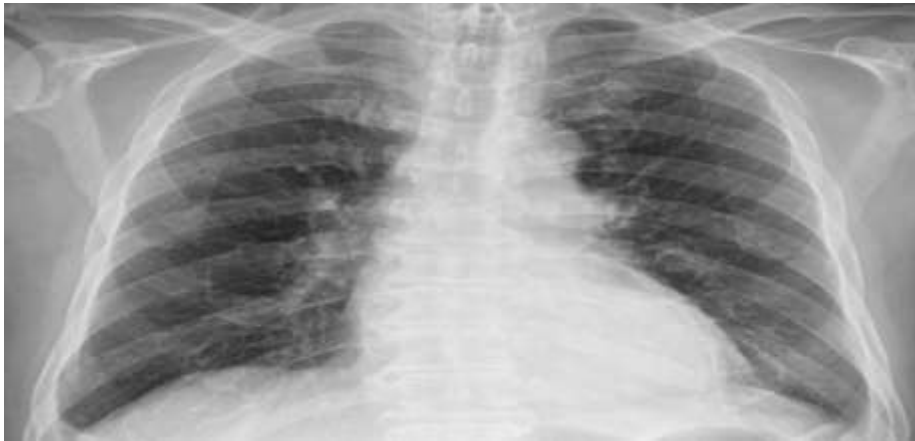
Chest X-ray showing resolving of hydropneumothorax.
